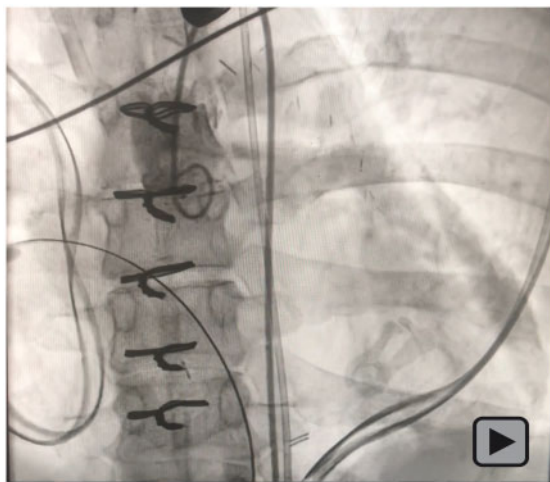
(A/B) A repeat coronary computed tomography angiogram revealed a patent right coronary artery and left anterior descending artery, but absent flow in the left circumflex artery (left). A repeat cardiac catheterization revealed persistent occlusion of the Takeuchi baffle by the vascular plugs without any leaks, patent left internal mammary artery to left anterior descending artery, patent right coronary artery and chronic total occlusion of the proximal left circumflex artery with right to left collaterals filling her obtuse marginal branches from the RCA. CTO, chronic total occlusion; LAD, left anterior descending; LCx, left circumflex artery; LIMA, left internal mammary artery; RCA, right coronary artery.
